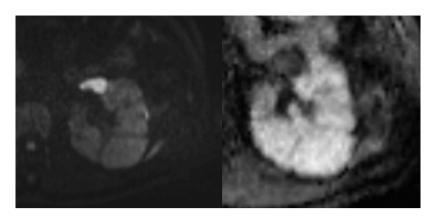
Features of free diffusion restriction on a DWI scan (b-value of 800) and an ADC map
